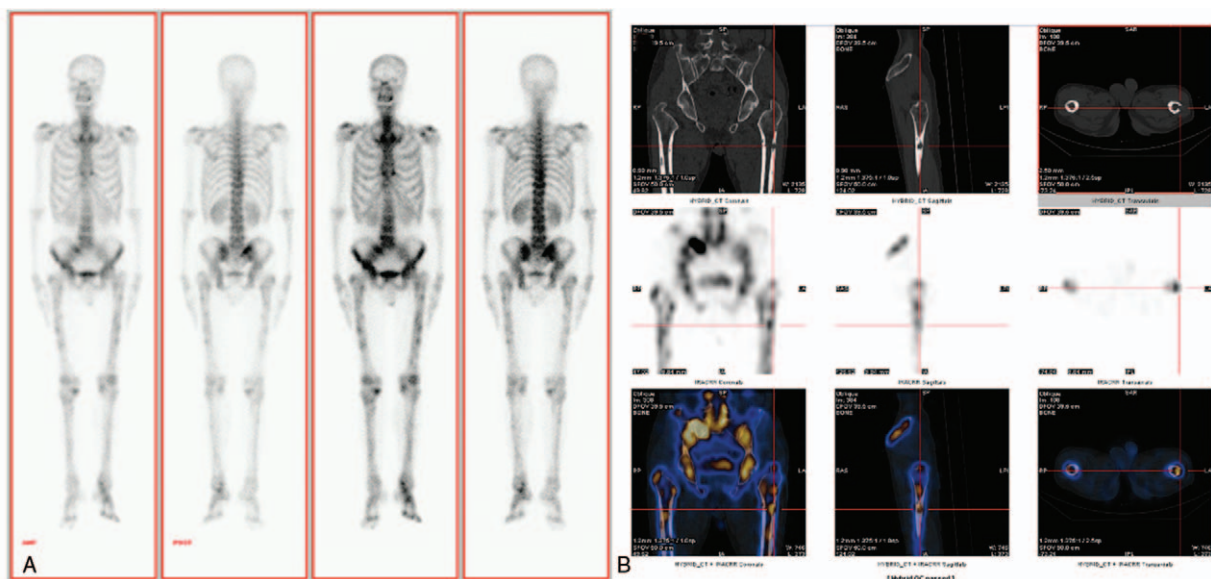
^{99m}Tc-MDP bone scintigraphy revealed increased tracer uptake in the pelvic and bilateral lower limb bones (A). SPECT/CT of the area extending from the lumbar spine to the upper two-thirds of the femur showed osteolytic lesions involving the lumbar spine, sacrum, pelvis, cortex, and medullary cavity of the femur, and high uptake around the lytic lesions (B).
